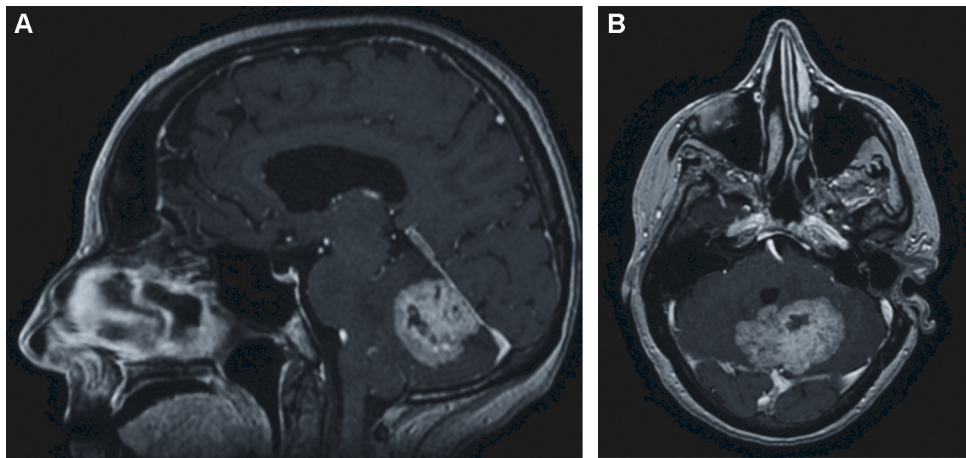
Sagittal MR imaging (1A) and axial (1B), T1 sequence with gadolinium enhancement, showing an unique cerebellar tumour. Note: a small supracerebellar infratentorial vein behind the tumour and in front of the torcular herophili.
